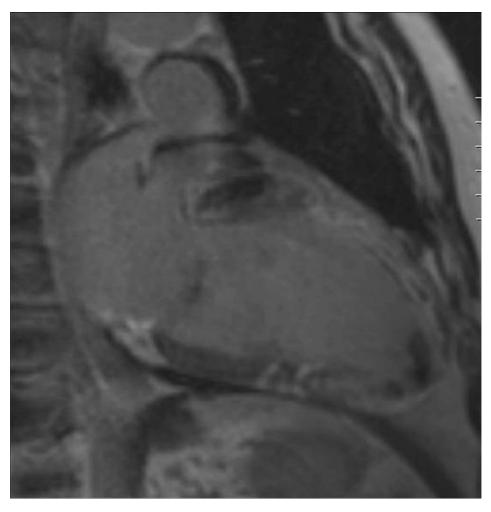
Contrast enhancement magnetic resonance image of an extensive, myocardial infarction with heterogeneous contrast enhancement (bright areas) with respect to the myocardial thickness, demonstrating the variability in the transmurality of the myocardial scar.
